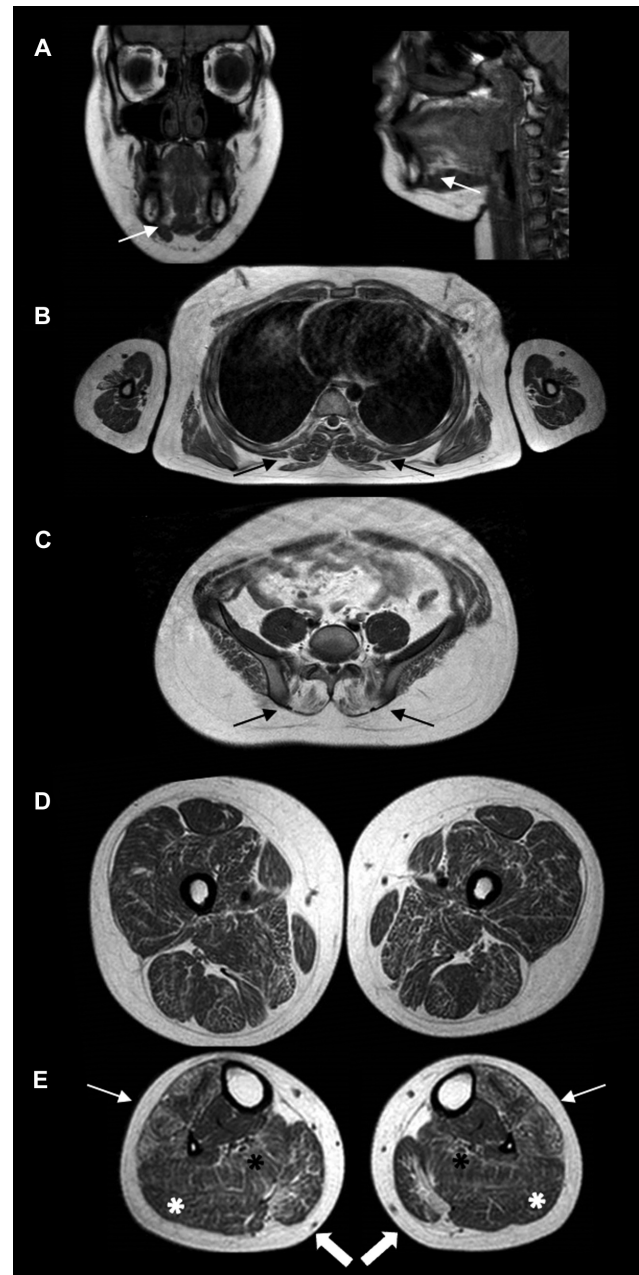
Representative images of T1-weighted whole body muscle magnetic resonance imaging (MRI) scans at 13 years of age are shown. Cranial scans displayed fatty substitution of the tongue (white arrow) (A). Paraspinal muscles were spared at the thoracic level (black arrows) (B) while involved at the lumbar one (black arrows) (C). Thigh scans showed a mild diffuse involvement (D); in the lower leg, the anterolateral compartment (tibialis anterior, extensor digitorum longus, peroneus longus) (white arrows) and medial gastrocnemius were mostly affected (white thick arrows), the latter with a subfascial rim of fatty replacement, with sparing of the lateral gastrocnemius (white asterisk). Soleus was affected to a lesser extent, more prominently in the distal part (black asterisk) (E).
